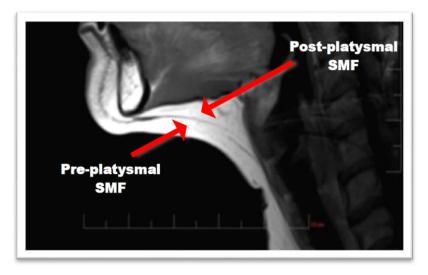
Sample MRI Image of Submental Fat
